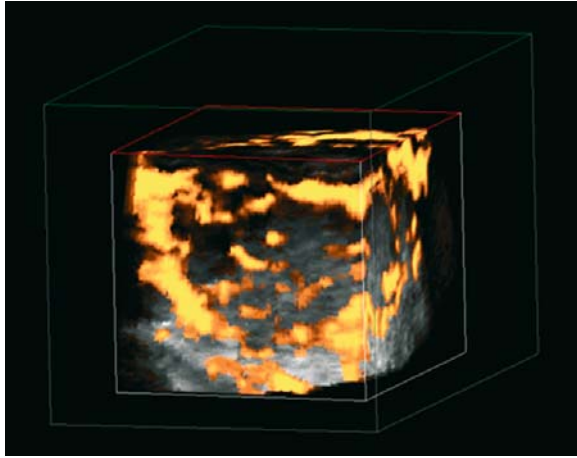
3D-display of color-Doppler ultrasound of a benign follicular adenoma: nonspecifically increased intra-nodular blood flow
